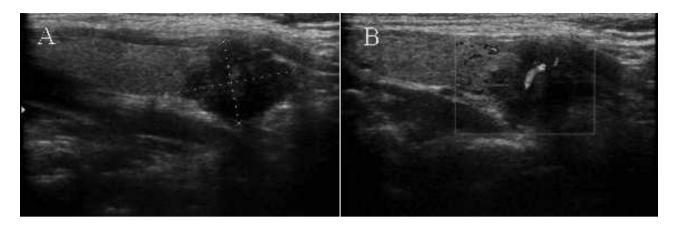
(A) Thyroid US reveals a hypoechoic, noncalcified, solid mass. (B) Color flow Doppler US reveals moderate vascularity within the lesion.
